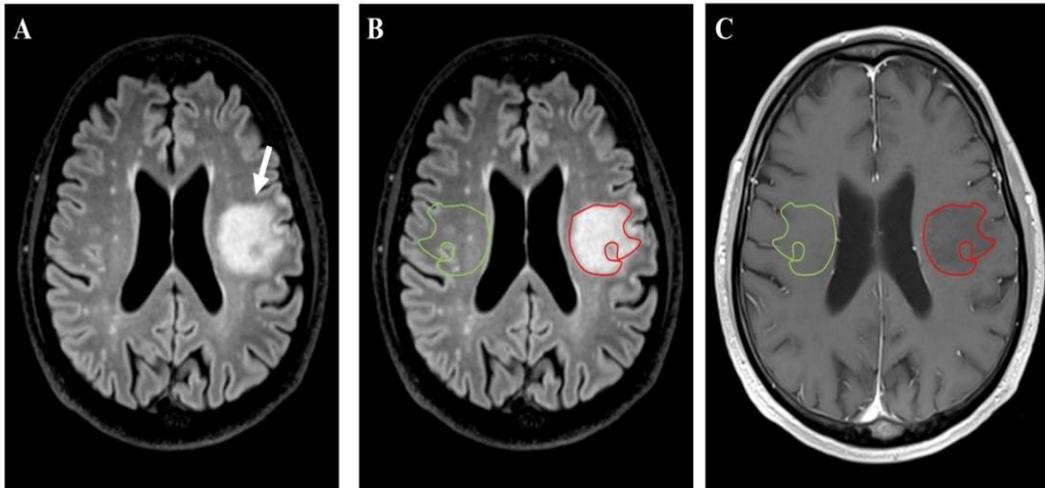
ROI selection for BBB permeability calculation. (A) FLAIR image. Lesion visible on the left hemisphere (white arrow). (B) ROI placement on FLAIR images. Ipsilateral ROI placement (red) and contralateral ROI placement (green). (C) ROI placement on the DCE sequence for BBB permeability assessment.
